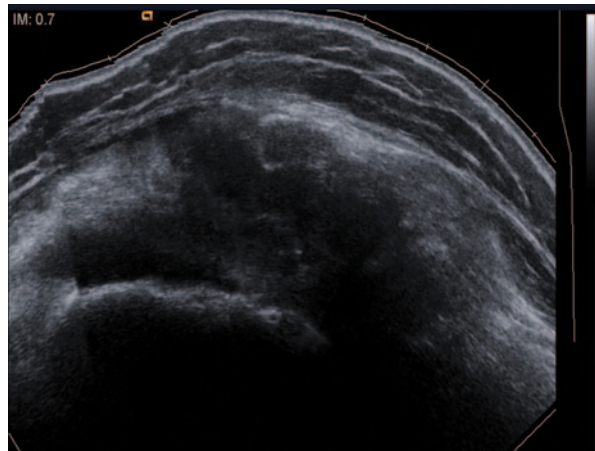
(a) Zoom image of the skin with thickening, subcutaneous edema and irregular hyper-echoic appearance of fat with blurred tissue planes with associated edema of deep layers. (b) Power Doppler signal shows hypervascularity
